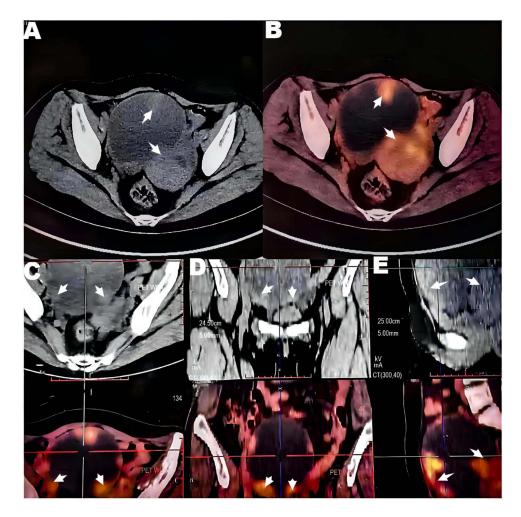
PET-CT (Case 1) A pelvic cystic-solid mass was considered to originate from right ovarian cystadenocarcinoma.
